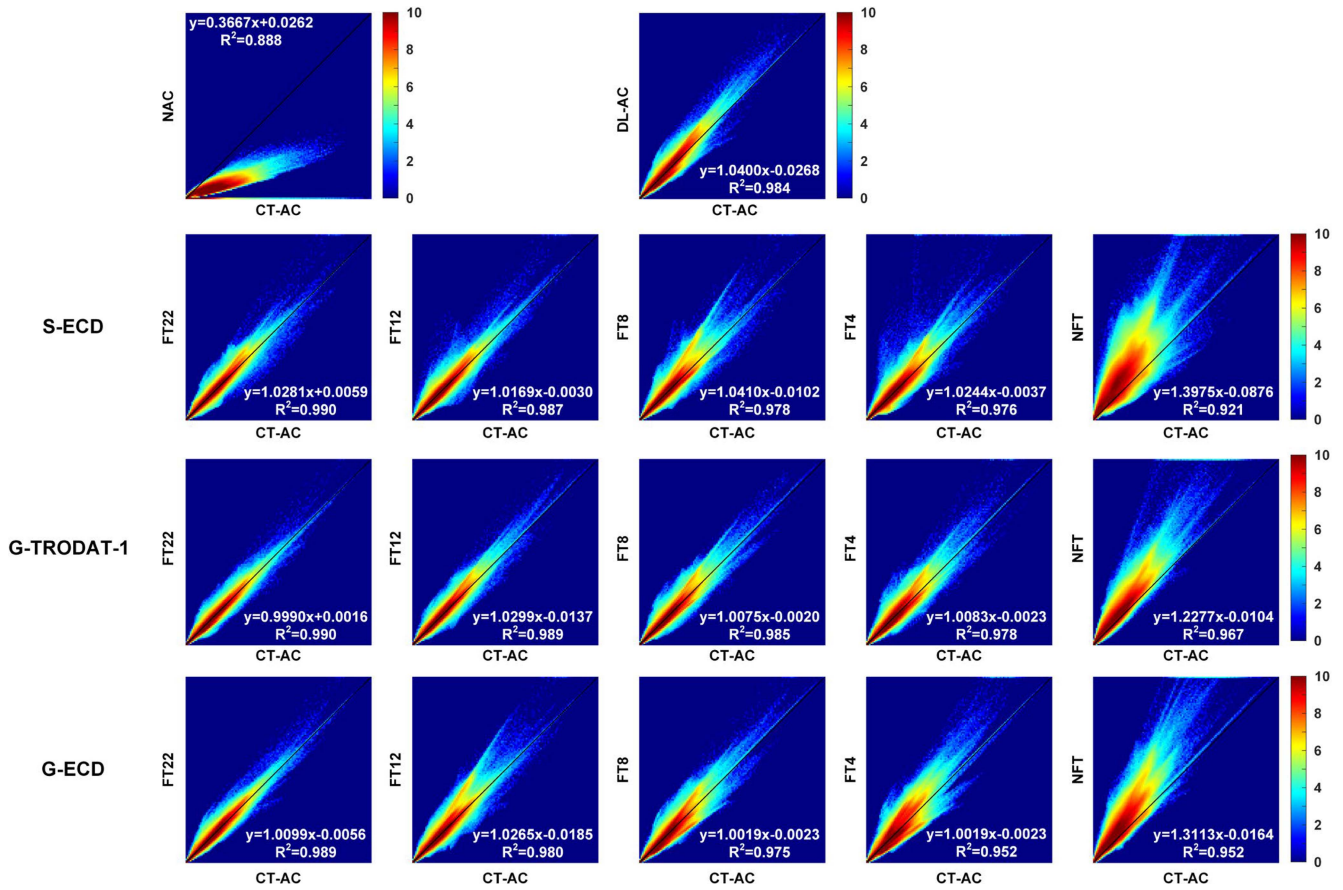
Joint histogram and linear regression analysis of NAC, DL-AC, different FT-AC, and NFT-AC methods on whole brain S-TRODAT-1 SPECT images across all tested patients using CT-AC as the reference.
